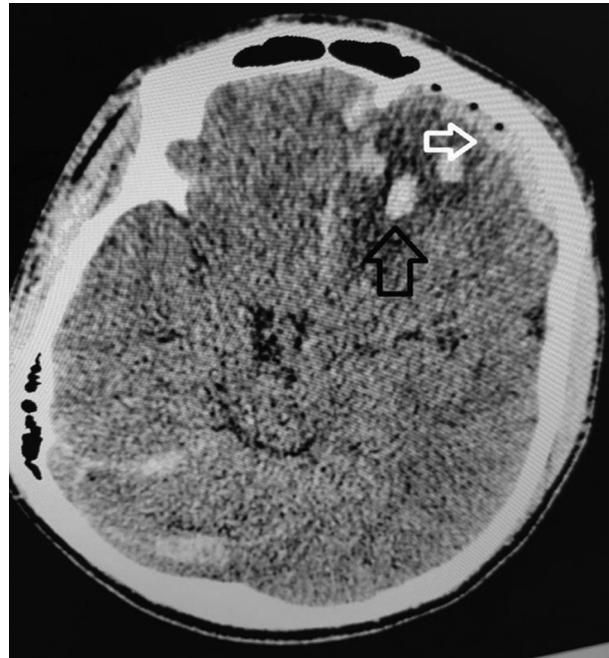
Non contrast CT head axial view brain window demonstrates multiple post traumatic contusions in the left frontal lobe (black arrow). Minimal adjacent subdural hematoma is also noted (white arrow).
